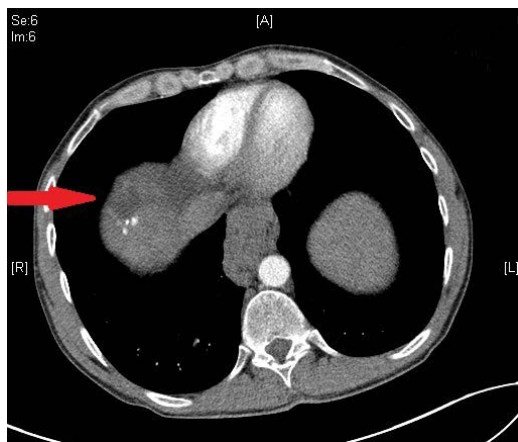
CT scan (arterial phase) three months after TACE.
